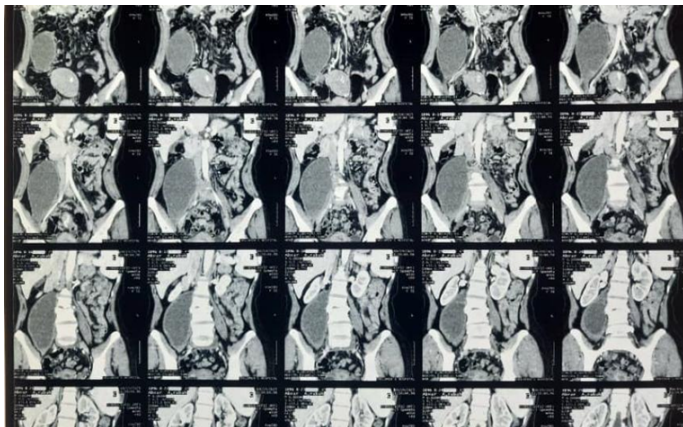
Coronal contrast-enhanced CT sections shows. (A) Large, encapsulated hypodense lesion (psoas abscess) occupying the right psoas muscle with prominent peripheral rim enhancement. (B) The abscess caused a significant craniocaudal tracking, extending from the L2 vertebral level down to the insertion of the iliopsoas muscle. (C) Evidence of L4-L5 intervertebral disc space narrowing and endplate erosion, characteristic of Pott's disease.
